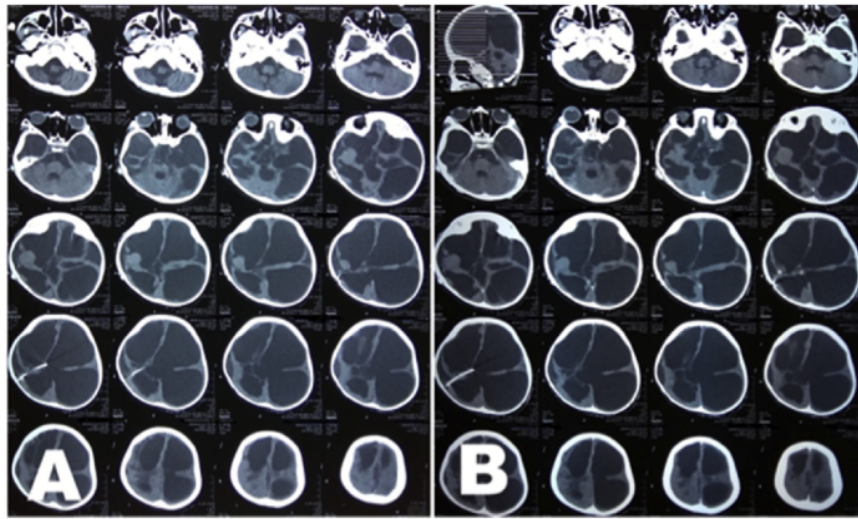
The fifth case, a 5-year-old boy had a wound on his stomach since 16 days before admission. Wound had bigger over time and tube appeared from the wound. Patient was planned to shunt exteriorization. A and B Pre procedural CT Scan.
